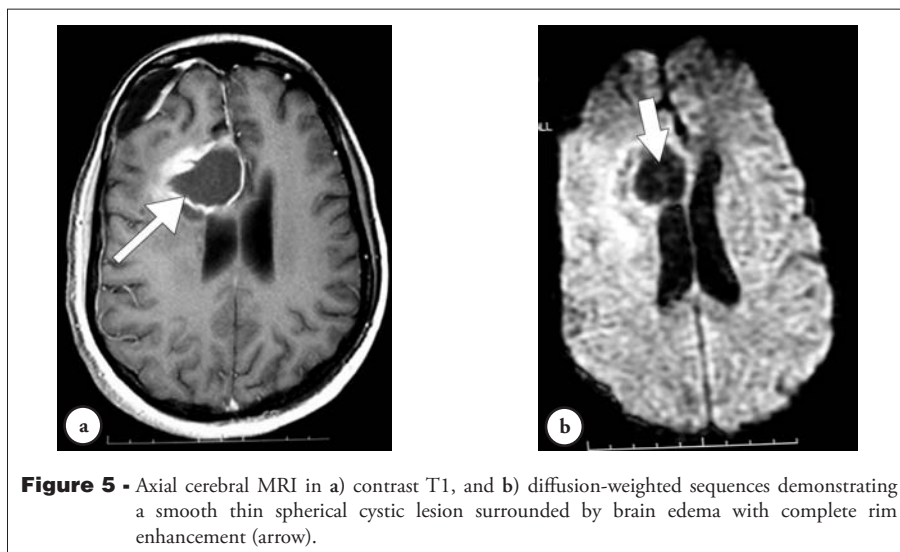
Axial cerebral MRI in a) contrast T1, and b) diffusion-weighted sequences demonstrating a smooth thin spherical cystic lesion surrounded by brain edema with complete rim enhancement (arrow).
